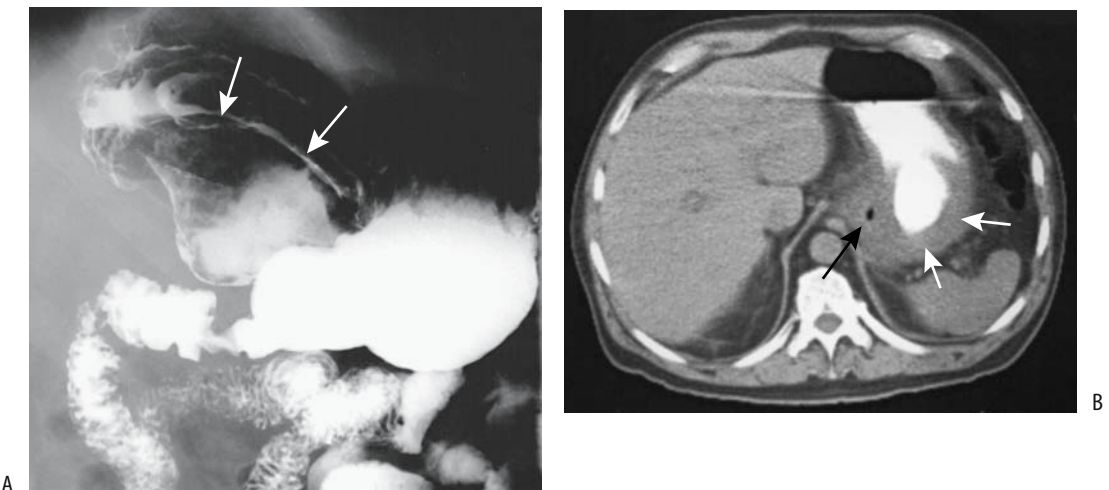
Gastric lymphoma. A: A barium study reveals a large, ulcerated tumor (arrows) in body of stomach. B: CT shows focal gastric wall infiltration (arrows). An atypical adenocarcinoma is in the differential diagnosis.
